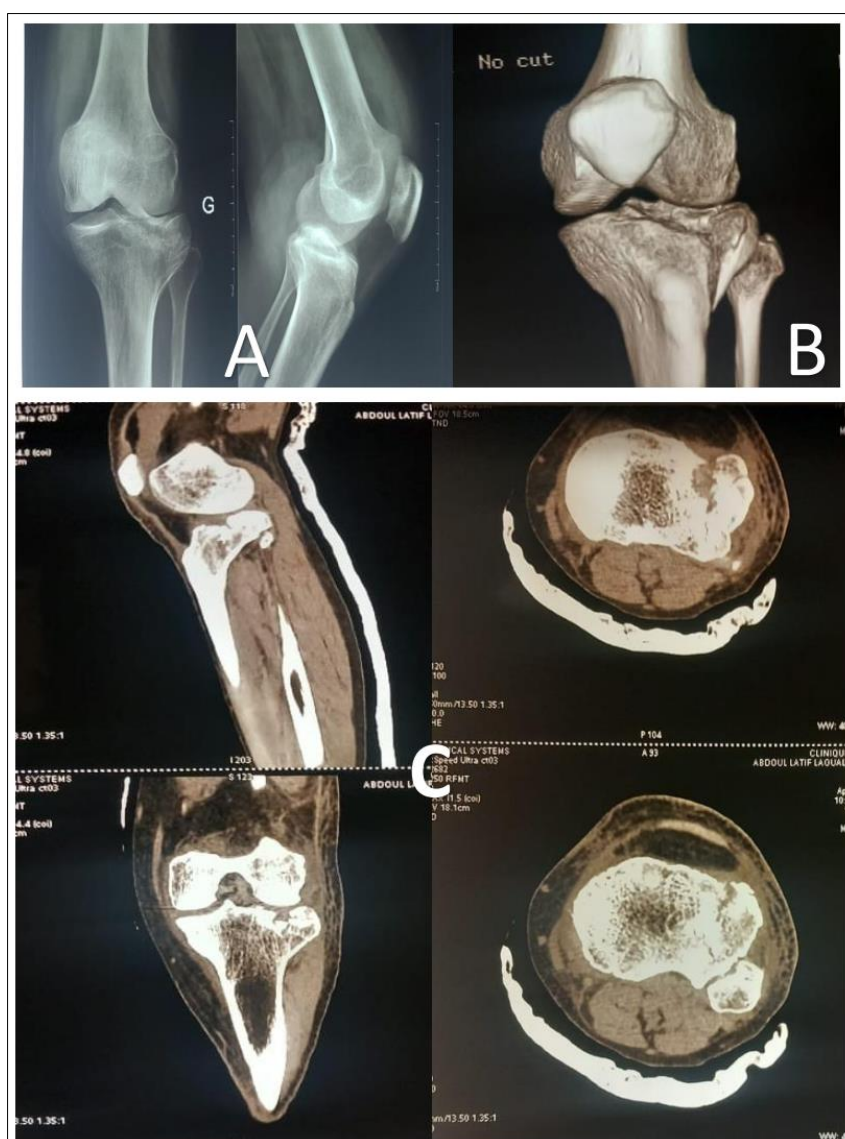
Radiographic image of the left F/P knee (A) and CT scan of the knee in 3d (B) and 2d (C) showing a depressed separation fracture of the lateral tibial plateau classified as Schatzker type II. (Image from the Department of Orthopaedic and Traumatological Surgery, HNABD, Professor Souna B S)
